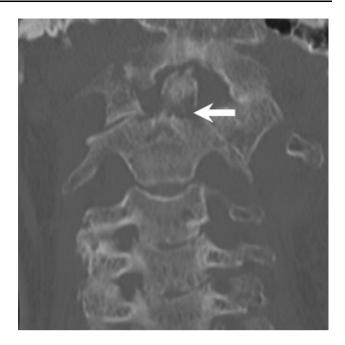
Coronal CT of the cervical spine shows type II fracture of the odontoid process (*arrow*)
